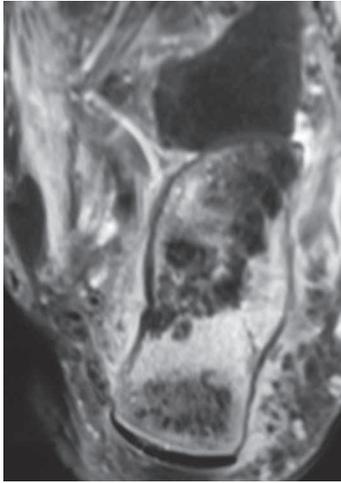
Preoperative MRI-coronal view
